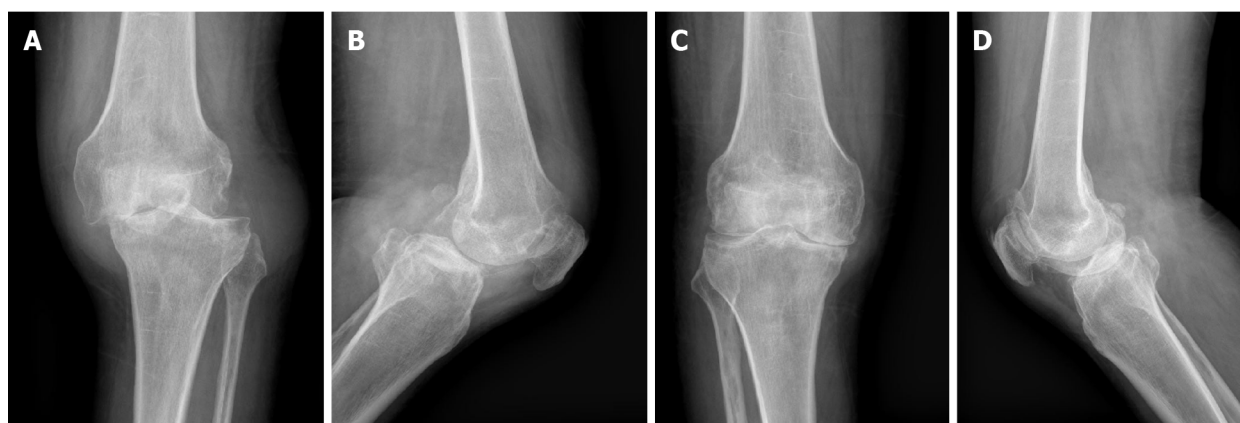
Preoperative X-ray images. A and B: Left knee front and lateral radiographs; C and D: Right knee front and lateral radiographs.
